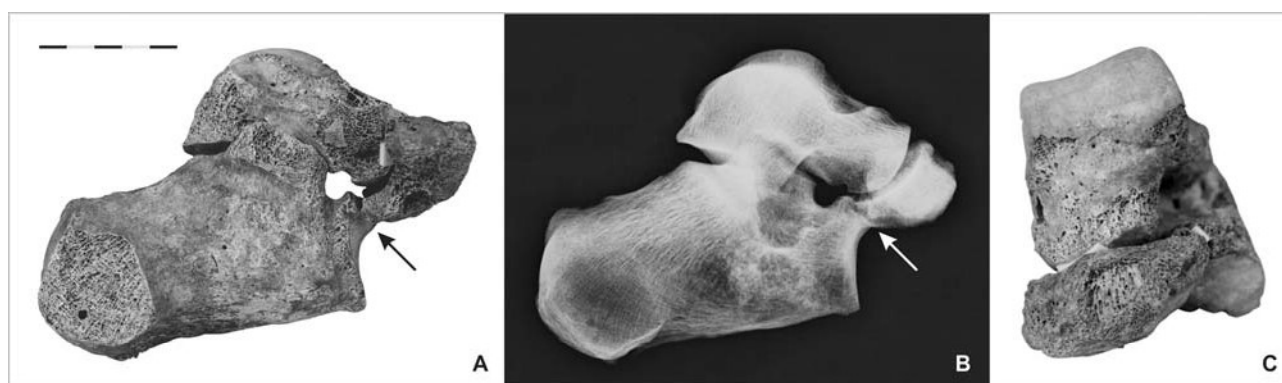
A, Calcaneonavicular coalition (shown with the black arrow) on the left tarsal bones of a 45–50year-old-female from Praha-Zličín (5th century, grave No. 530/19). B, Radiograph shows a round protrusion of the calcaneus with the atypical contact surface in contact with the navicular bone referred to as the anteater nose sign (shown with the white arrow) (Chapman 2007). C, Supero-anterior view of the calcaneonavicular coalition. The scale corresponds to 5 cm; the dimension is the same for all figure parts. Photo edited by Jana Vachová. A and B were reproduced with permission by Vargová *et al.*, 2016 and the main editor of the *Interdisciplinaria archaeologica*, Figure 12 p. 24.
